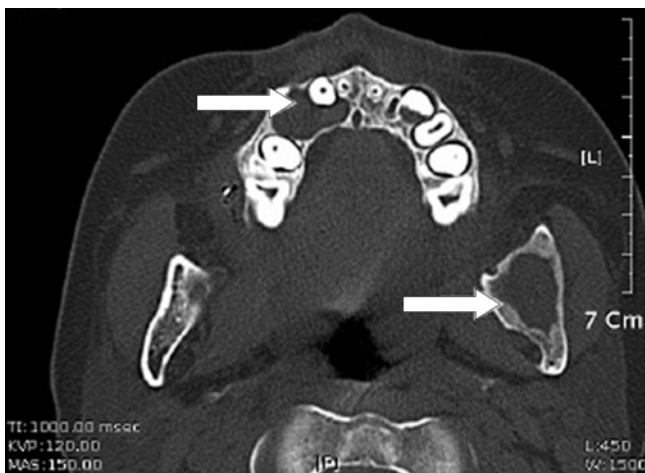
Axial CT scan at mid-maxilla level shows multiple odontogenic cysts in the left mandibular angle and right parasymphysis (arrows).
